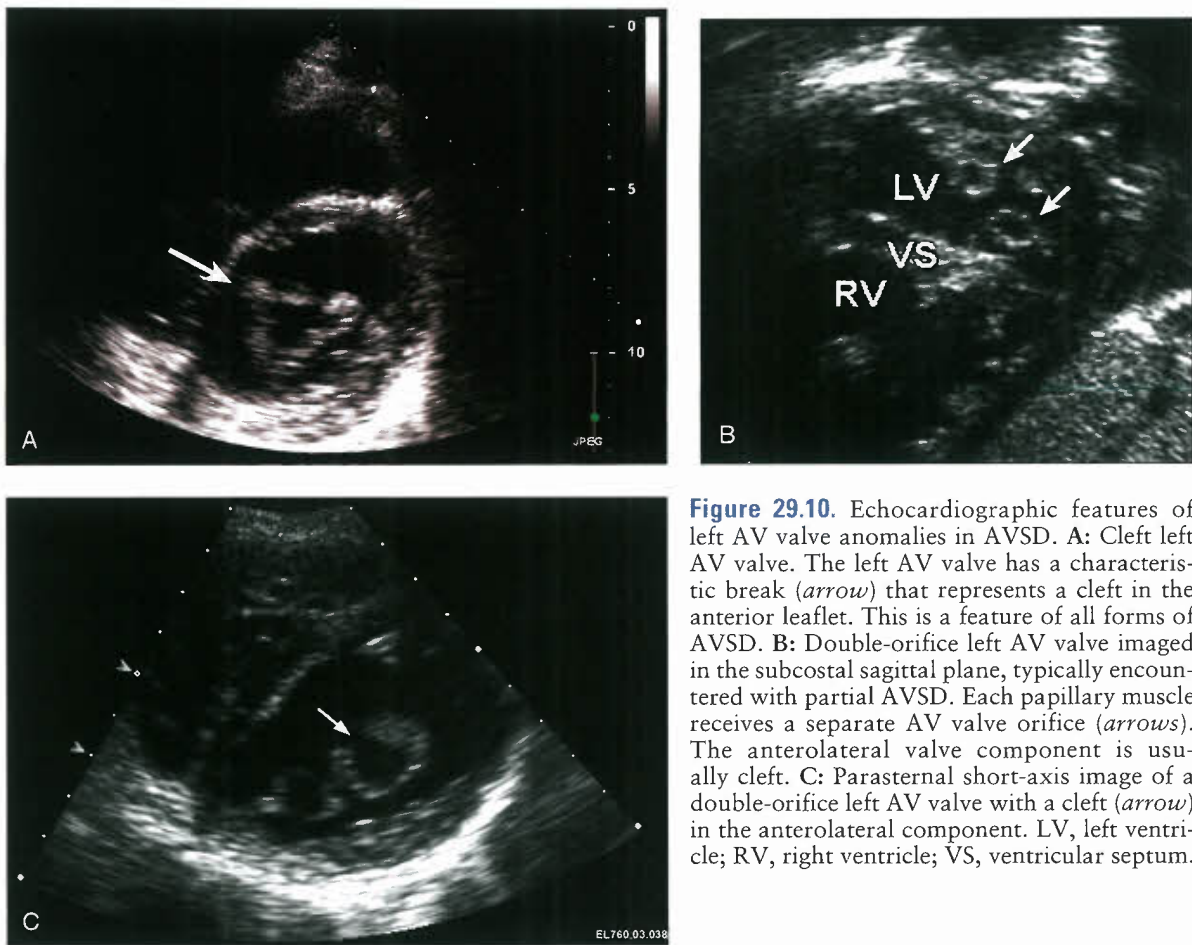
Echocardiographic features of left AV valve anomalies in AVSD. A: Cleft left AV valve. The left AV valve has a characteristic break (*arrow*) that represents a cleft in the anterior leaflet. This is a feature of all forms of AVSD. B: Double-orifice left AV valve imaged in the subcostal sagittal plane, typically encountered with partial AVSD. Each papillary muscle receives a separate AV valve orifice (*arrows*). The anterolateral valve component is usually cleft. C: Parasternal short-axis image of a double-orifice left AV valve with a cleft (*arrow*) in the anterolateral component. LV, left ventricle; RV, right ventricle; VS, ventricular septum.
